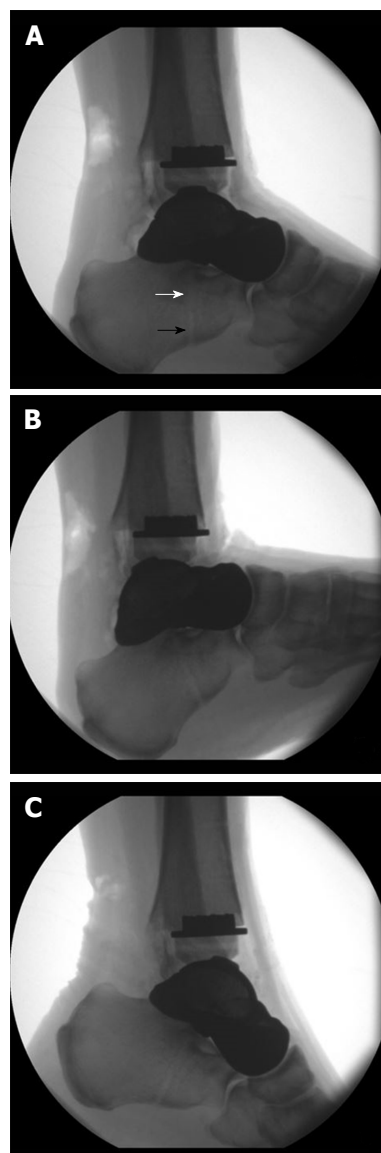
Radiographic examination of the maximum range of motion of the ankle joint after internally bracing of the customized hemiprosthesis. A: Neutral position; B: Maximum dorsiflexion 22°; C: Maximum plantarflexion 28°. Note the visible bone tunnel in the calcaneus (black arrow) with the interference screw inside the proximal part of the tunnel (white arrow) to prevent tunnel widening by indirect aperture fixation at the subtalar joint performed percutaneously from plantar.
